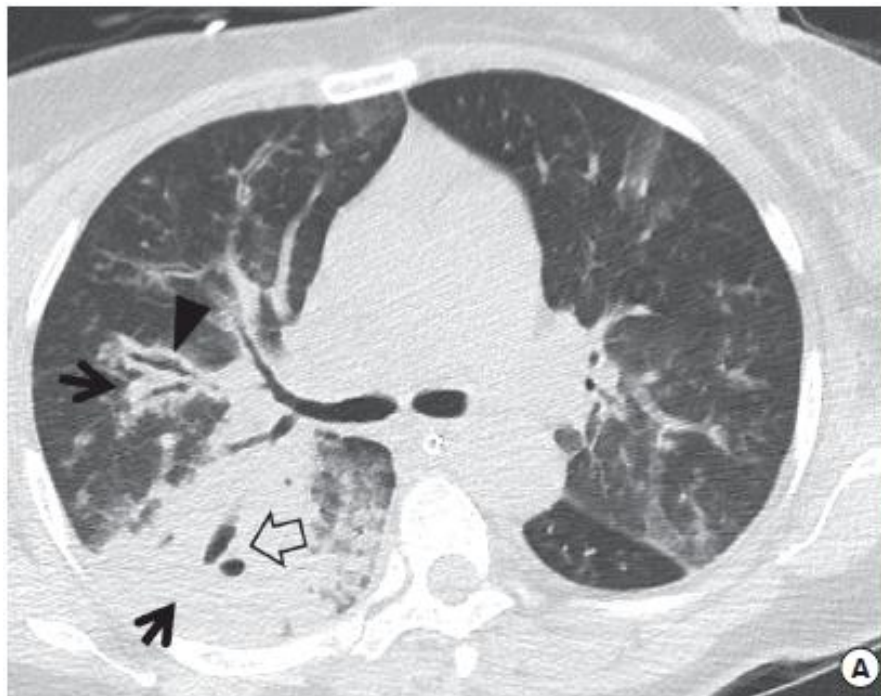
Airway invasive aspergillosis in a 56-year-old woman with acute myelogenous leukemia. (A) Lung window image of computed tomography (CT) scans (2.5-mm-section thickness) obtained at level of main bronchi shows dense area of consolidation in a predominantly peribronchial distribution (arrows). Also note diffuse bronchial wall thickening (arrowhead) representing aspergillus tracheobronchitis. Cavity formation is seen within the consolidation (open arrow). (B) Bronchoscopy revealed multifocal mucosa hyperemia and pseudo-membrane formation (arrowheads) in the bronchial lumen. (C) Follow-up CT Image obtained 3 days later shows rapid progression of multifocal consolidation in both lungs. The patient expired despite the use of antifungal agents.
